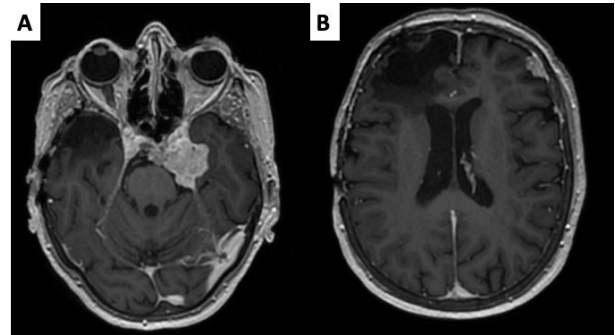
Initial MRI (A–B): Contrast-enhanced coronal and sagittal T1-weighted images reveal a solid sellar and suprasellar mass located at the skull base, extending posteriorly into the prepontine and interpeduncular cisterns, with approximate dimensions of 30 × 30 × 35 mm. Early postoperative MRI (C–D): Contrast-enhanced coronal and axial T1-weighted images demonstrate postoperative changes with residual tumor measuring approximately 30 × 20 × 22 mm.
